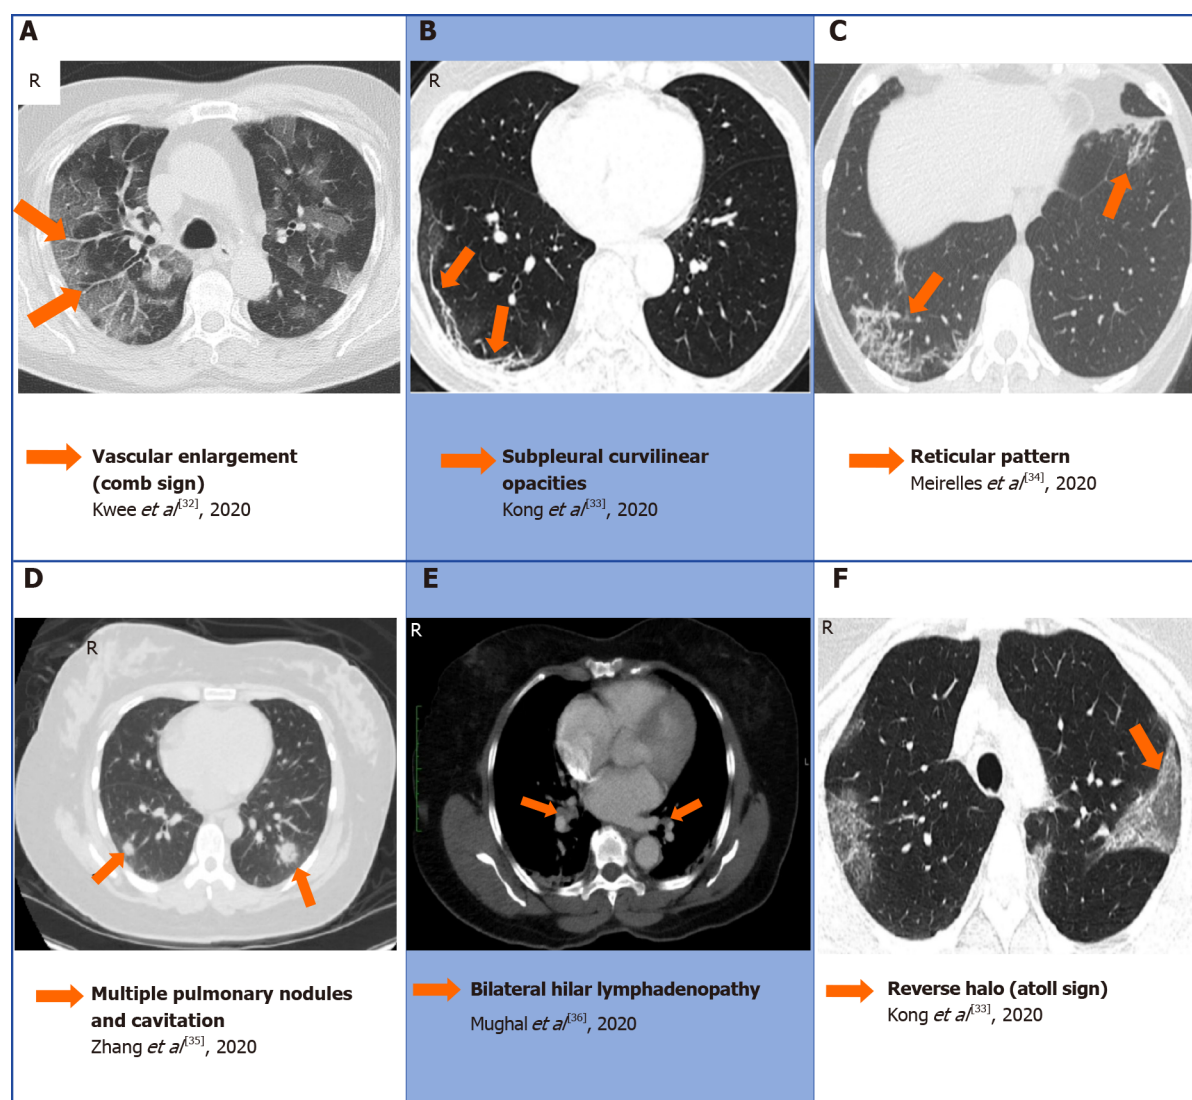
A collection of chest computed tomography that displays some of the atypical findings of coronavirus disease 2019 pneumonia [32-36]. A: Comb sign in the right lobe characterized by vascular enlargement; B: Curvilinear opacities in the subpleural area; C: Reticular pattern bilaterally; D: Multiple nodules and cavitation; E: Bilateral hilar lymphadenopathy; F: Atoll sign also known as reverse halo. A: Citation: Kwee TC, Kwee RM. Chest CT in COVID-19: What the radiologist needs to know. *Radiographics* 2020; 40: 1848-1865. Copyright ©The Author(s) 2021. Published by Radiographics; B and F: Citation: Kong W, Agarwal PP. Chest imaging appearance of COVID-19 infection. *Radiology: Cardiothoracic Imaging* 2020; 2: e200028. Copyright ©The Author(s) 2020. Published by the Radiological Society of North America, Inc; C: Citation: Meirelles GSP. COVID-19: A brief update for radiologists. *Radiologia Brasileira* 2020; 53: 320-328. Copyright ©The Author(s) 2020. Published by Radiology brasil; D: Citation: Zhang Q, Douglas A, Abideen ZU, Khanal S, Tzamas S. Novel coronavirus (2019-nCoV) in disguise. *Cureus* 2020; 12: e7521. Copyright ©The Author(s) 2020. Published by Cureus; E: Citation: Mughal MS, Rehman R, Osman R, Kan N, Mirza H, Eng MH. Hilar lymphadenopathy, a novel finding in the setting of coronavirus disease (COVID-19): A case report. *Journal of Medical Case Reports* 2020; 14: 124. Copyright ©The Author(s) 2020. Published by BMC.
